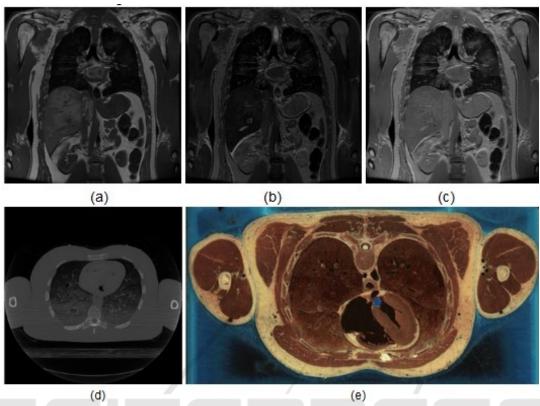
Images available on the website of The Visible Human Project: (a) MRI T1-; (b)MRI T2-; (c) proton density images; (d) CT; (e) color axial image (U.S. National Library of Medicine, 2019).
